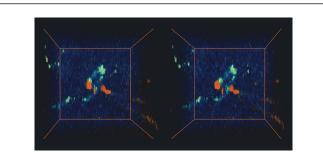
A stereoscopic image of high-magnification Doppler OCT angiography of the feeder vessel. A pair of images is presented for crossed-eye viewing. The distribution of the Doppler signals from the retina, choroid, and the space between the RPE and Bruch's membrane are color-coded with blue, green, and red, respectively.
